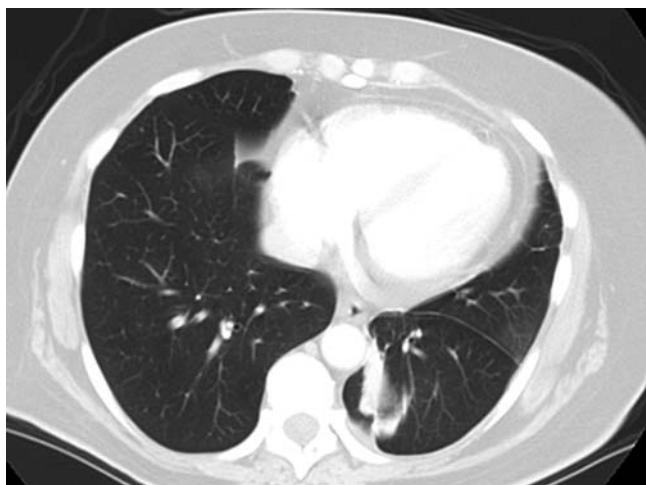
CT scan of chest showing ground glass opacity in the posterior segment of left lower lobe. Tissue examination showed a non-mucinous type of bronchioloalveolar carcinoma.
